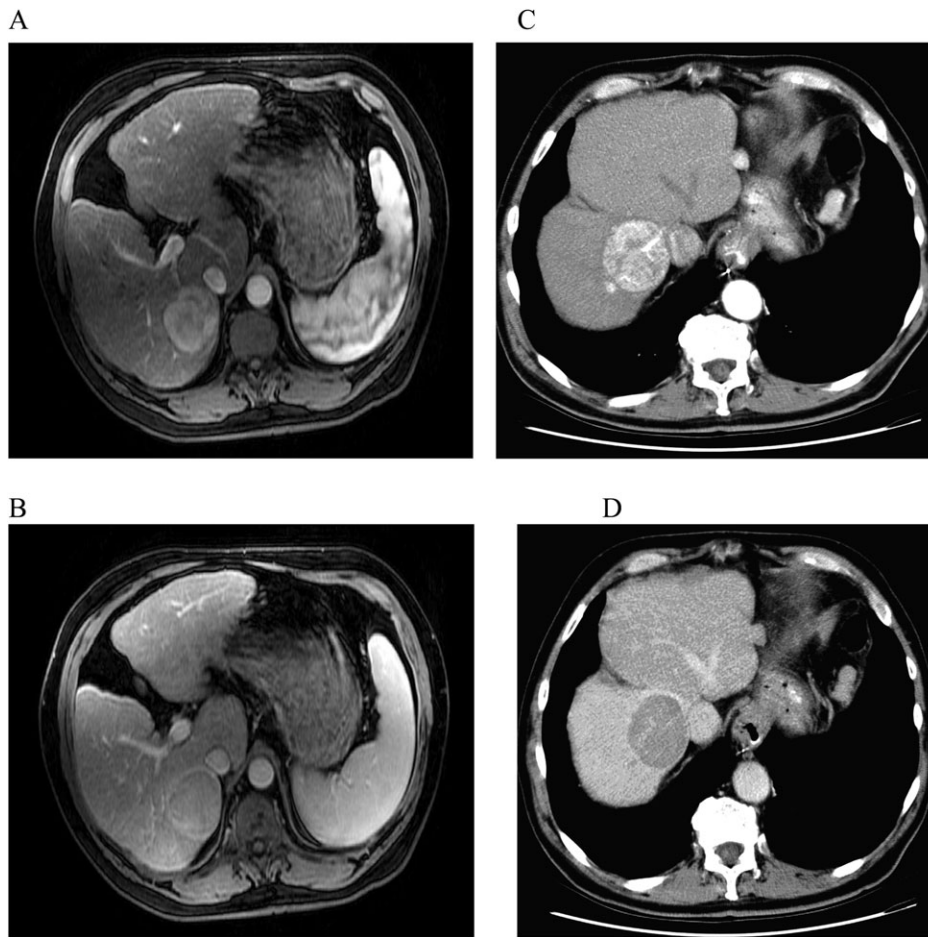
MRI scans for a liver showing (A) arterial enhancement and (B) portal venous washout and CT scans for a liver showing (C) arterial enhancement and (D) portal venous washout.
